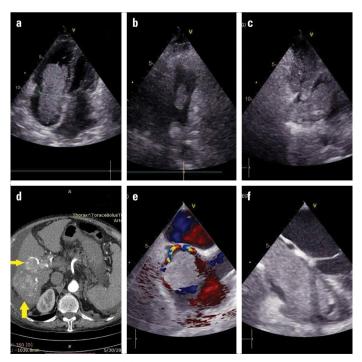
Panel figure. (a) Well-defined giant mass occupying the right atrium (RA), protruding into the right ventricle (RV), and significantly obliterating the tricuspid valve; (b) protrusion in the pulmonary artery (PA); (c) origin site in the inferior vena cava (IVC); (d) highly typical CT for hepatocellular carcinoma diagnosis (arrows); (e, f) transesophageal echocardiography revealing a giant mass occupying the right chambers
